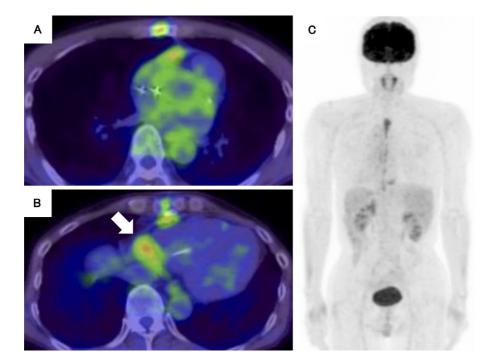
Fluorodeoxyglucose positron emission tomography (FDG-PET). FDG-PET showed an increased uptake only in the mass in the right atrioventricular groove (B, arrow) and postoperative wound (A) two months after the operation. No other uptake was observed in the salivary glands or lymph nodes (C).
